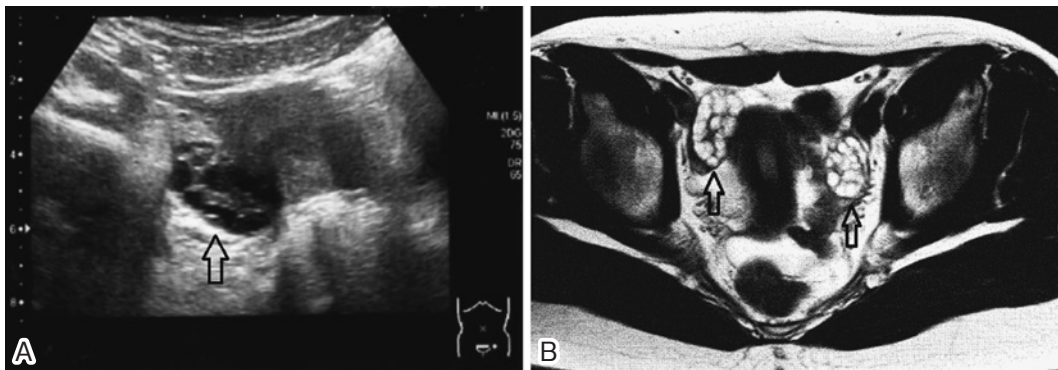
Abdominal imaging showed multiple cysts in the patient's ovaries (A: ultrasonography, B: magnetic resonance imaging). The outline arrows indicate polycystic ovaries.
